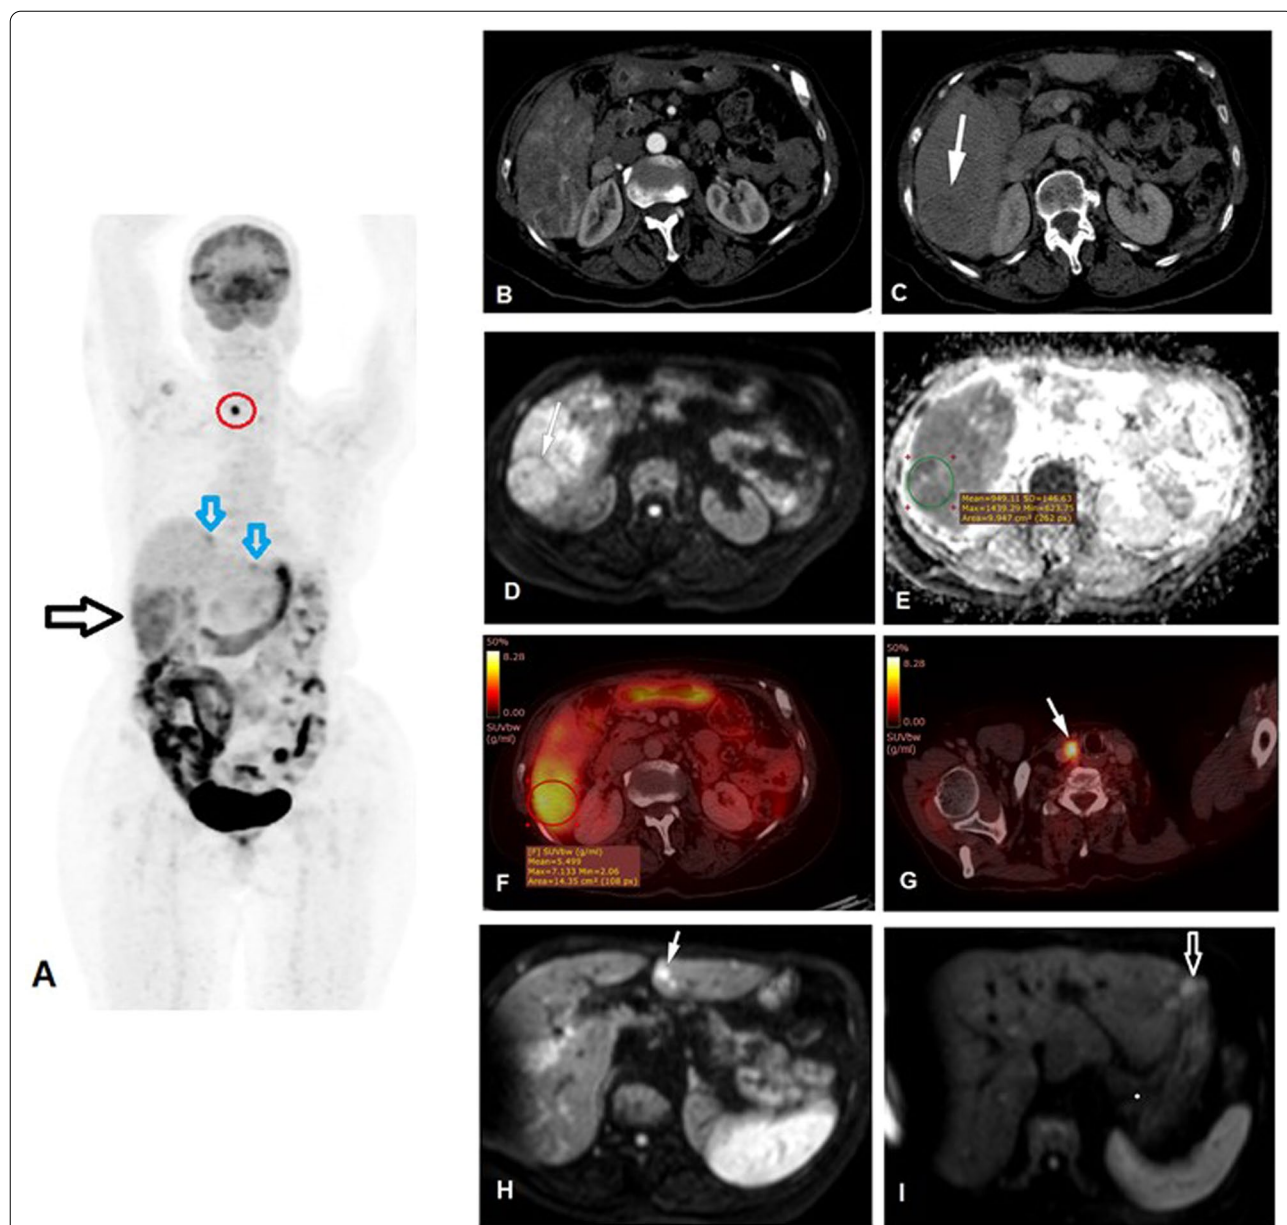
A 69-year-old female patient with a history of segment VI HCC, had both RFA and ethanol injection. TR-LR viable lesion with increased FDG uptake and diffusion restriction, also had active metastatic cervical lymph node, with two de novo hepatic lesions. MIP image (A) showing focal hepatic right lobar lower segmental increased tracer uptake (horizontal black arrow), two left lobar upper segmental small nodular tracer uptake (vertical blue arrows), and lower neck focal increased nodular uptake. Arterial (B) and portovenous (C) triphasic CT show residual/recurrent viable tumoral tissue (white arrow) shows APHE and washout. DWI (D) and ADC map (E) shows restricted diffusion in the ablated HCC (white arrow) with mean ADC value measuring 949 mm²/s. Fused PET/CT images show increased FDG uptake in the ablated HCC (red circle) achieving SUVmax of 7.1 (F) and focal increased FDG uptake in a right lower deep cervical lymph node (white arrow) (G). De novo two small hepatic left lobar lesions with restricted diffusion are noted at the DW MR axial images (H and I)
